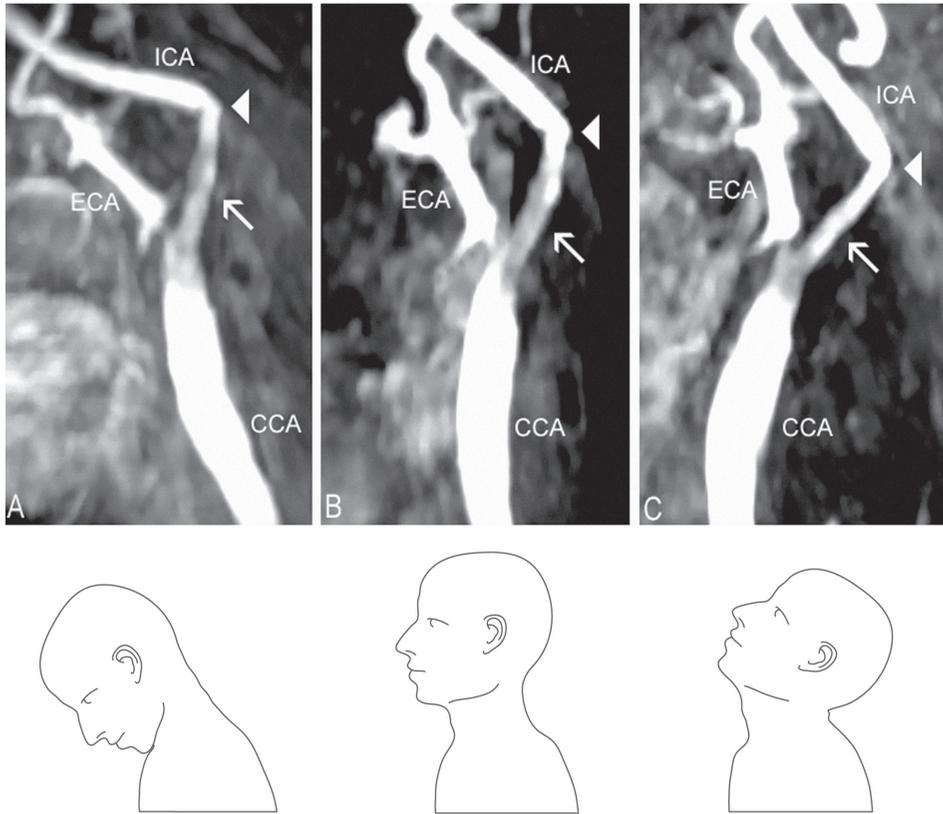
MR images of a 66-year-old man following stent (arrows) placement. Images showing the carotid artery from the same viewpoint, during three different head positions. In the Neutral head position (B) there is an angulation of the distal stent junction (arrowheads) of 56° . Note the increase in this angulation, up to 85° when the head is bent Forward (A). In the bent Backward head position (C) the same angulation is decreased to 49° .
